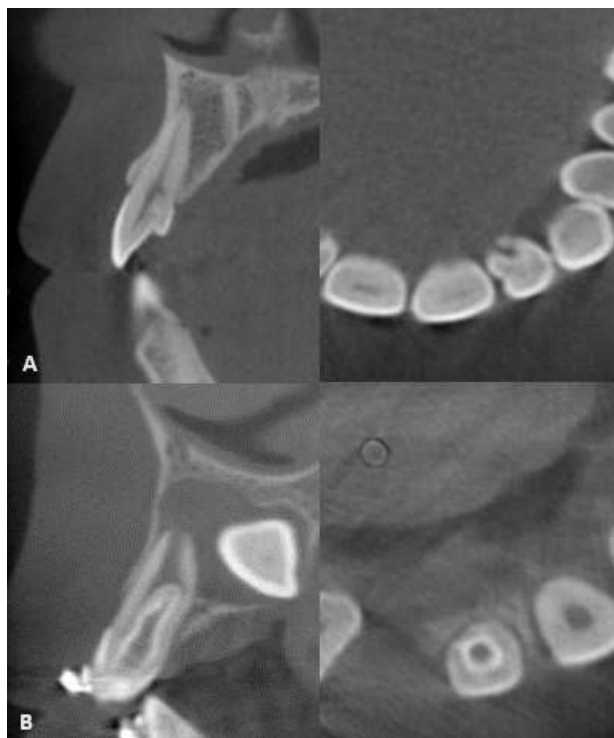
From left to right, sagittal and axial views of CBCT scans showing A) Type I and B) Type II classifications.
